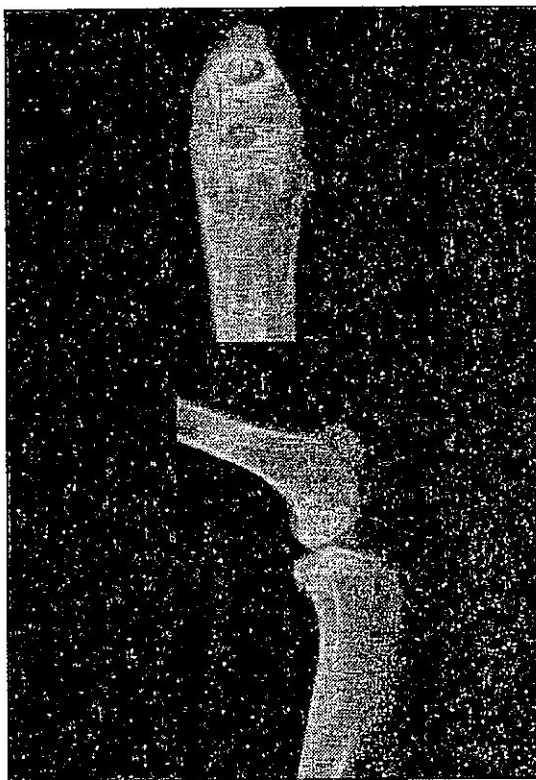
X-ray picture of operated knee joint, after 36 weeks, showing no degenerative changes.
